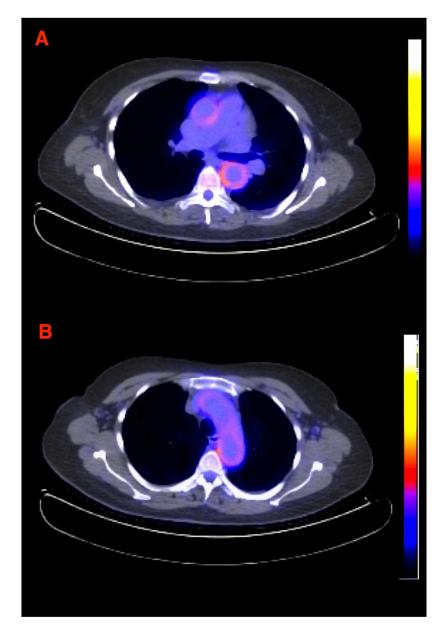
FDG-PET/CT scan demonstrating the distribution of inflammation through active uptake of FDG in the (A) ascending and descending aorta and (B) the aortic arch in the transverse plane.
